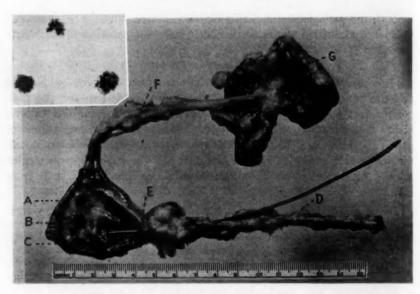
Pancreodochocholecystostomy was performed two years ago. A, B, C indicate the stones found in the gallbladder (G); D, the pancreas with the pancreatic duct partially opened; a probe is passed through the anastomosis (E) into the gallbladder. F indicates the bile duct. The insert is a roentgenogram of stones casting dense calcium shadows.
